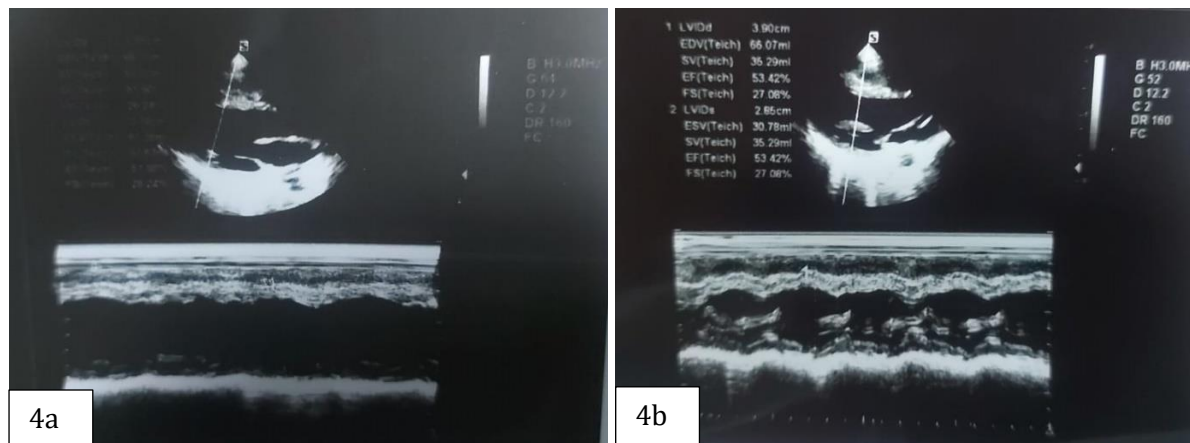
follow-up Echocardiography (a) 2nd month (b) 6th month
